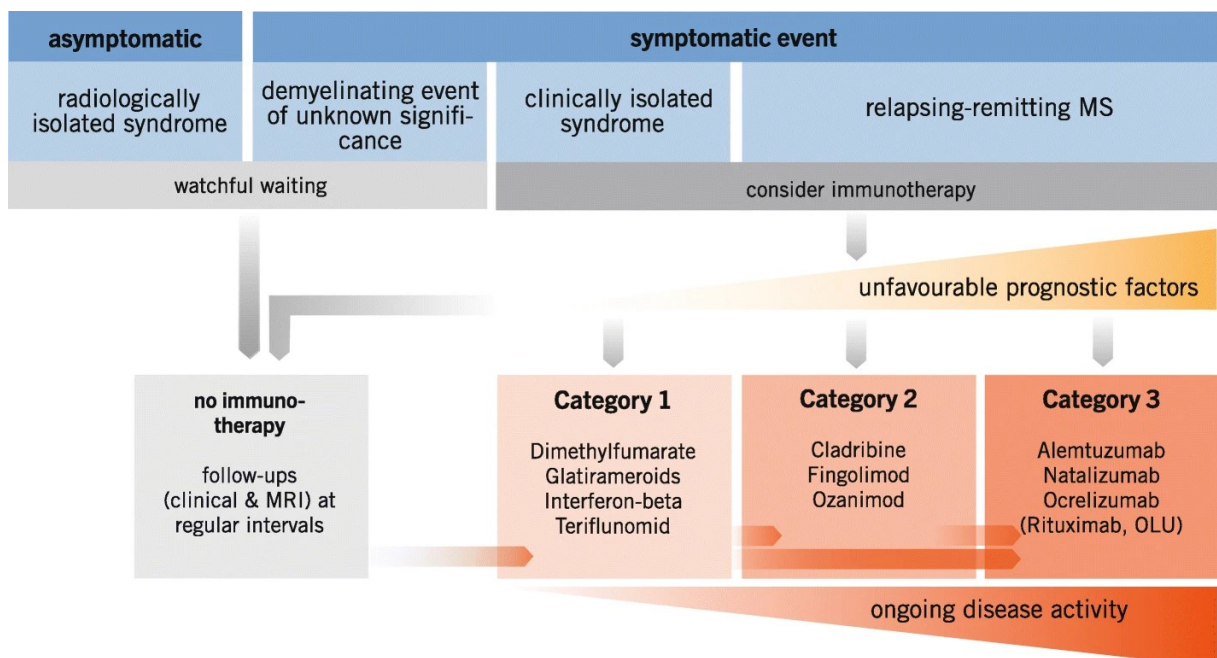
Therapeutic algorithm for relapsing-remitting multiple sclerosis (RRMS) by the German Neurological Society (DGN). MS: multiple sclerosis, MRI: magnetic resonance imaging, OLU: off-label use. Reprinted with the permission of Springer Nature (73).
